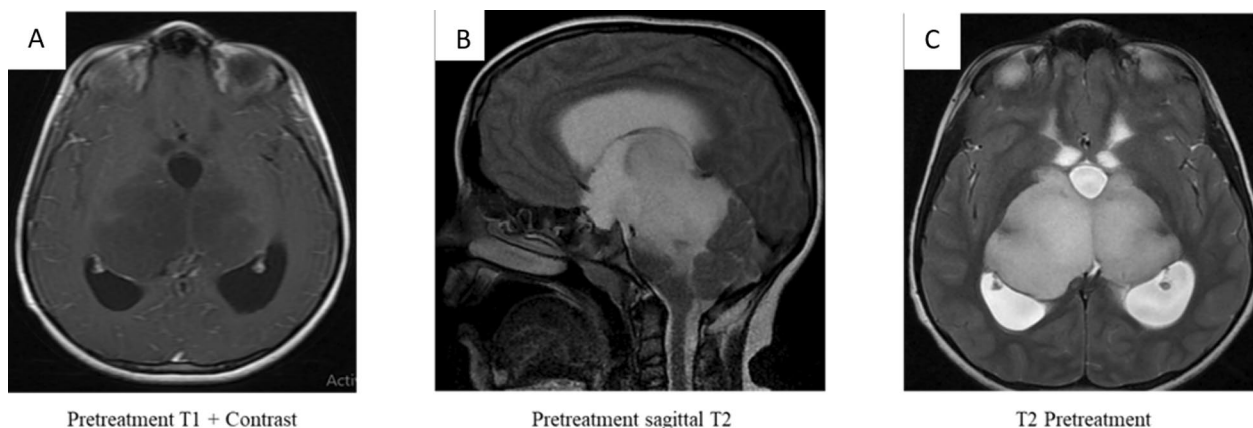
Pre-treatment MRI of the brain showing diffuse intrinsic pontine glioma
